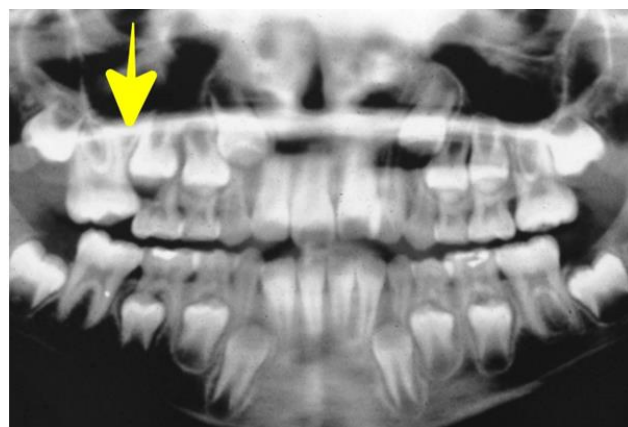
Panoramic Radiograph. Yellow arrow showing the maxillary right permanent first molar blocked under the distal surface of the maxillary right primary second molar (Source: Author).
